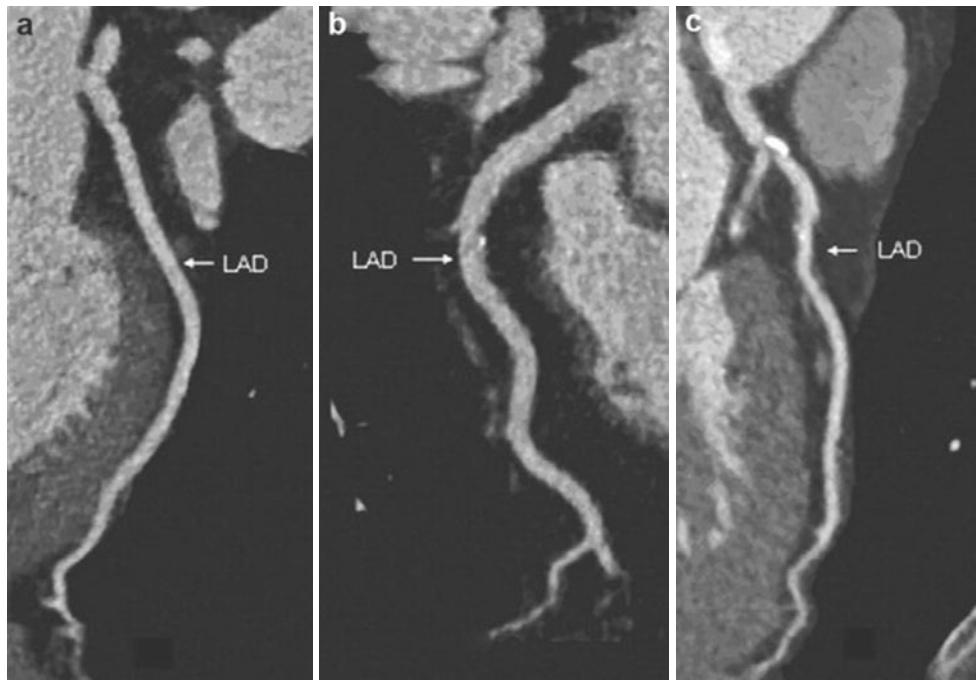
This figure shows coronary CTA images from three patients: a 47-year-old man with substernal chest pain and dyspnea with normal coronary arteries (*arrow*) (a), a 58-year-old man with accelerating chest discomfort with mild coronary disease (*arrow*) (b), and a 60-year-old woman with progressive dyspnea and atypical chest discomfort with significant mixed plaque (*arrow*) (c) [26]. LAD left anterior descending artery
